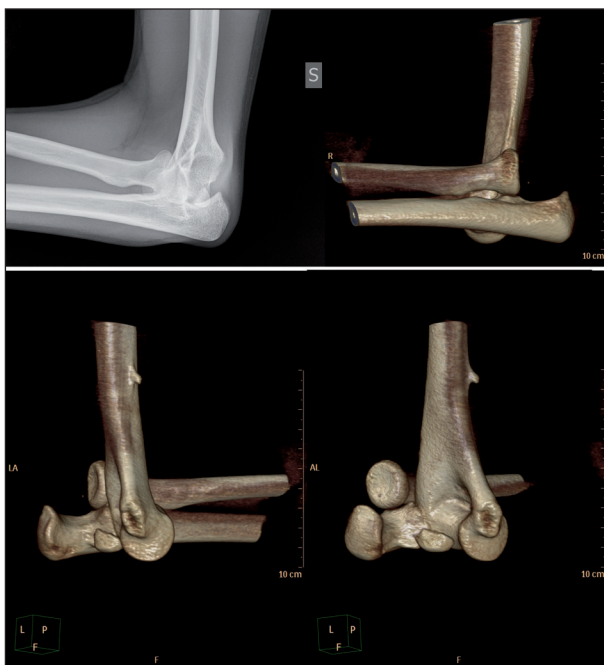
X-ray and 3D CT with fracture-dislocation of the left elbow.
